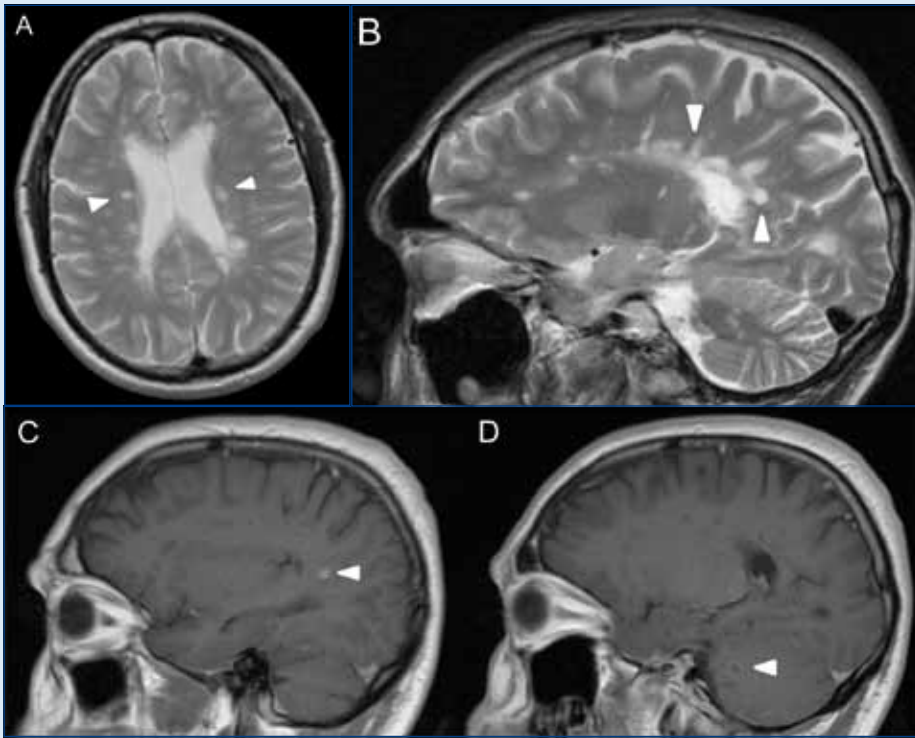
Typical magnetic resonance imaging appearances for multiple sclerosis. a. T2 weighted magnetic resonance imaging scan, with axial views demonstrating periventricular white matter lesions. b. T2 weighted magnetic resonance imaging scan demonstrating involvement of the corpus callosum, forming a distribution referred to as 'Dawson's fingers'. c. Contrast-enhanced T1 weighted magnetic resonance imaging scan, demonstrating contrast-enhancing lesion. d. Contrast-enhanced T1 weighted magnetic resonance imaging scan demonstrating a ring appearance.
